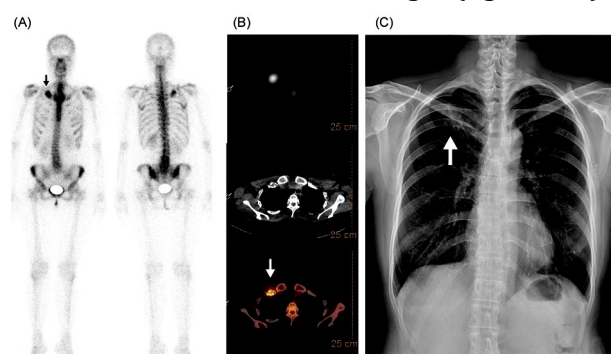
(A) The planar bone scan: a hot spot in anterior aspect of right 1st rib. (B) The SPECT/CT study: typical radiolucent and sclerotic change with bone expansion in fibrous dysplasia over right 1st rib was noted on the reference CT images. (C) This finding was not pointed out on the first interpretation of a previous chest plain film.
